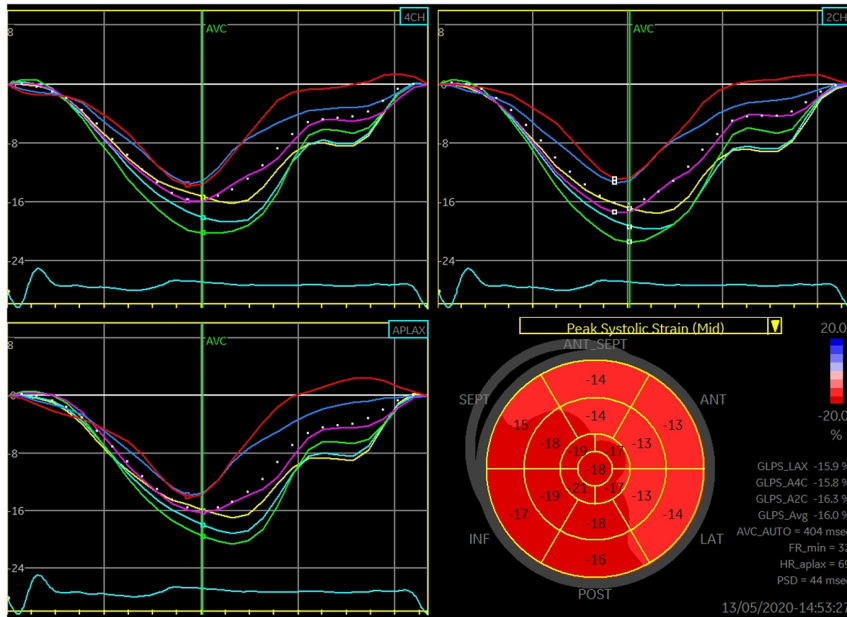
Global longitudinal strain after adrenalectomy. The green and purple curves represent apical segments. GLPS, global longitudinal peak strain; 4CH, apical four chamber view; 2CH, apical two chamber view; APLAX, apical long-axis view; MID, mid-wall; AVC, aortic valve closure; ANT-SEPT, anterior-septal; ANT, anterior; LAT, lateral; POST, posterior; INF, inferior; SEPT, septal; HR, heart rate.
